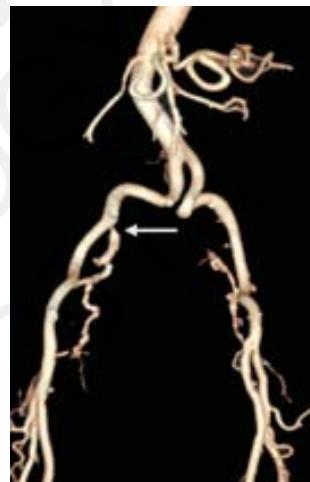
Computed tomography angiography showing stenosis of right ostial internal iliac artery.
